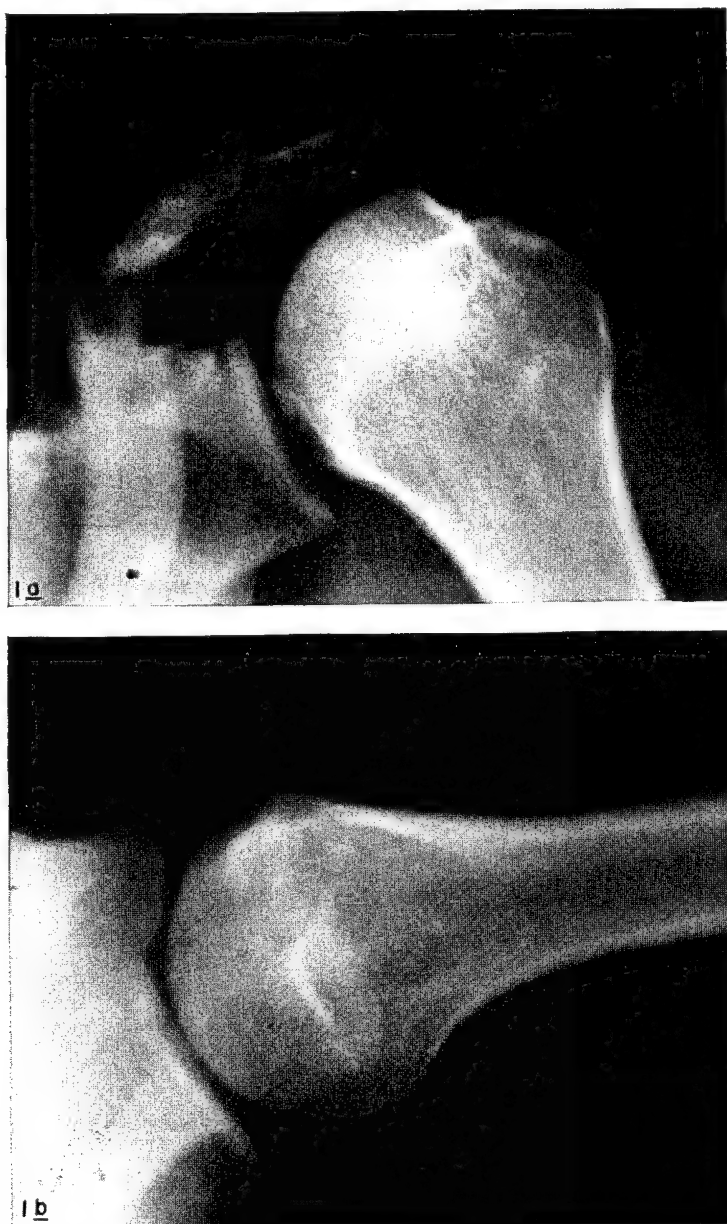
Roentgenograms showing definite grooving of the postero-lateral portion of the humeral head in a patient with recurrent shoulder dislocation. (1a) Anteroposterior view showing vertical line of sclerosis at the margin of the defect. (1b) Lateral view of the groove.
